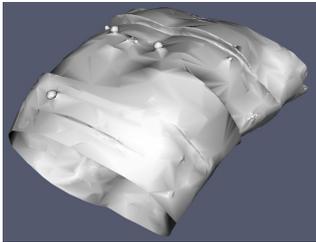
3D Torso Model from CT Scans.
